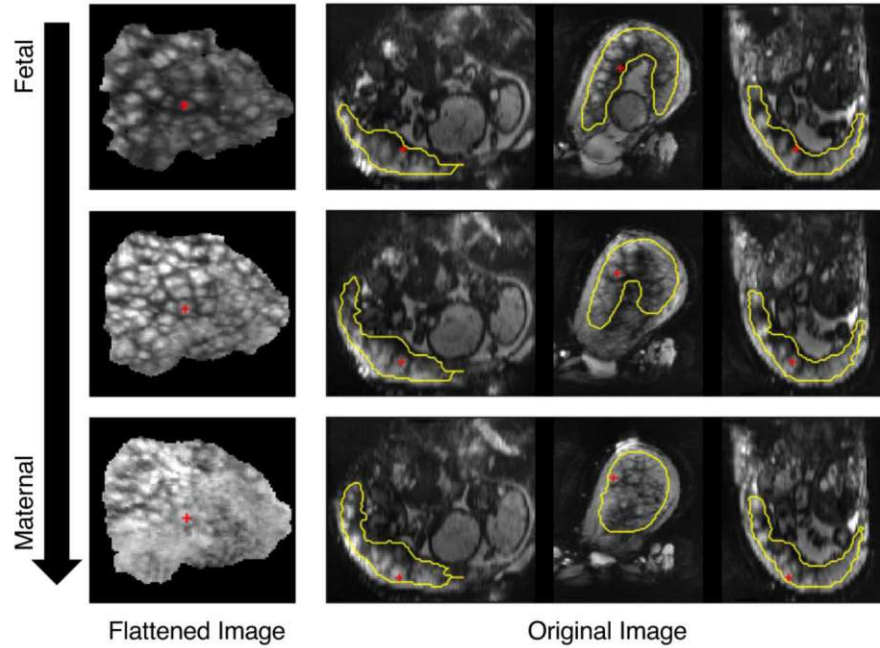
Comparison of MRI slices from the flattened placenta volume (left) with corresponding cross-sections from the original volume (right) using the parallel planes template (from [6])
